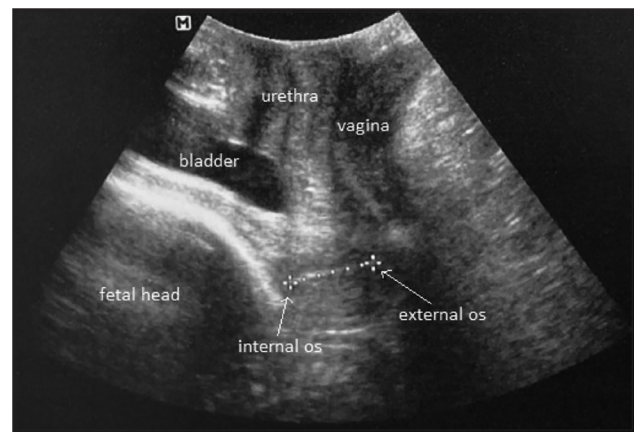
Transperineal ultrasound image for measuring cervical length.
